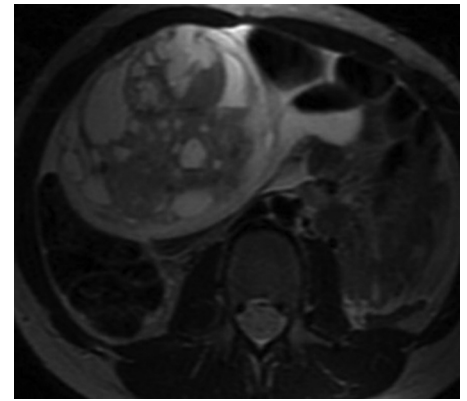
Axial T2WI showing a large right ovarian tumor, with a sponge-like appearance compatible with an ovarian juvenile granulosa cell tumor. T2WI, T2-weighted imaging.
